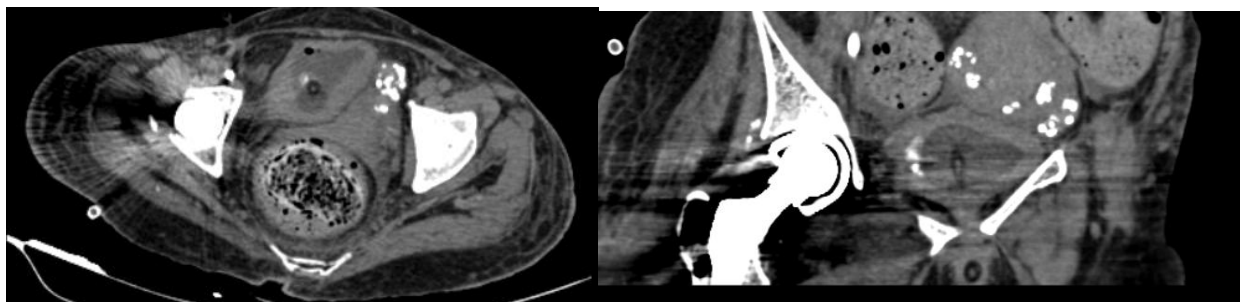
Axial and coronal sections of the abdomen on CT imaging, through the urinary bladder shows few calcific foci in the urinary bladder, and along the Foley's bulb
